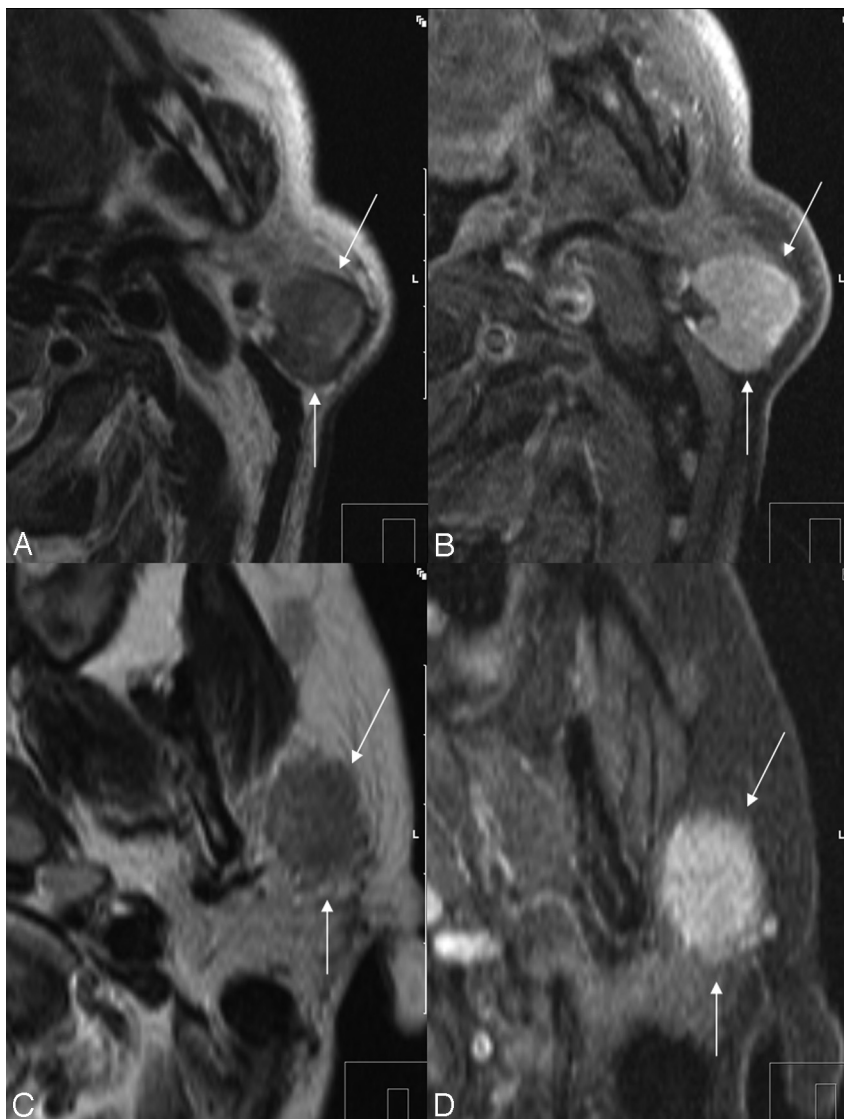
Ill-defined margins as a sign of malignancy. *A*, Warthin tumor with a well-defined border on axial T2-weighted imaging (arrows) in a 66-year-old man. *B*, Postcontrast T1-weighted imaging of Warthin tumor (arrows). *C*, Ill-defined margin (arrows) of a mucoepidermoid carcinoma in a 61-year-old male patient with SI similar to that in the Warthin tumor (*A*). Note the low SI on the T2-weighted image, which is also a malignant predictor. *D*, Postcontrast T1-weighted image of the ill-defined mucoepidermoid carcinoma (arrows).
